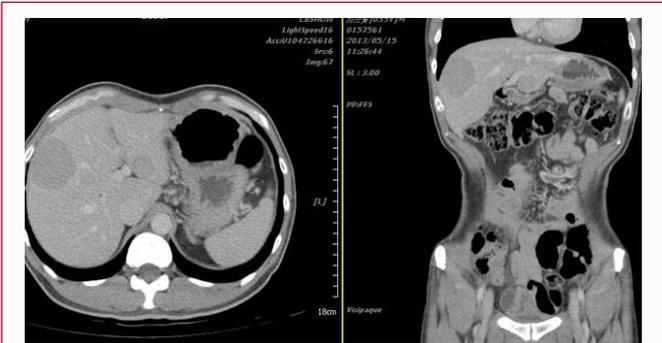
The abdominal CT revealed two isodense tumors in liver (S3,S8) and multiple paraaortic lymph adenopathy (not shown).
